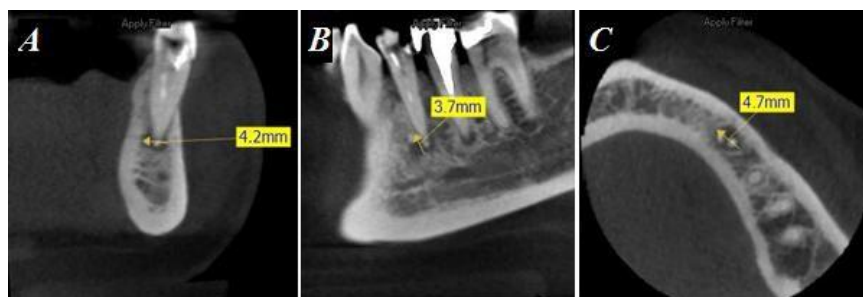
a. C.M., age 40. Periapical granuloma 4.3. Initial CBCT
